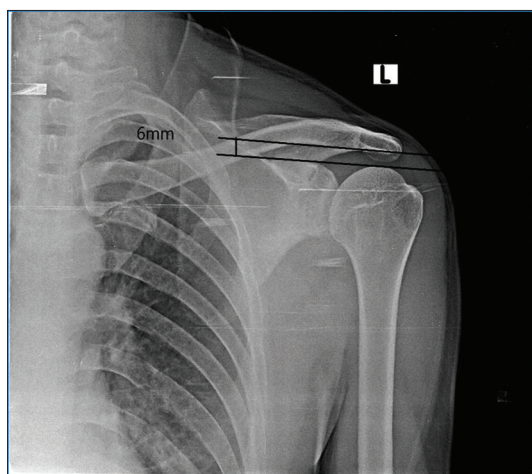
A-P radiograph left shoulder joint in neutral position shows reduced acromiohumeral interval (6 mm)
